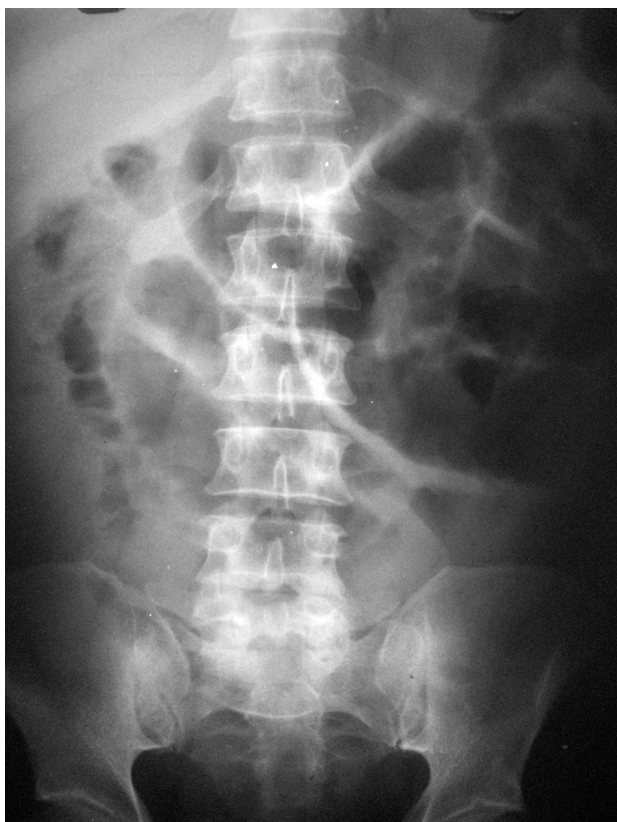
Abdominal radiography.
